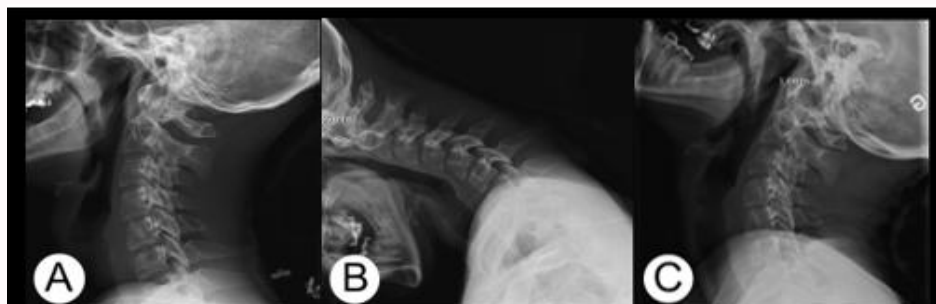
(A) Preoperative radiograph neutral position. (B) Preoperative radiograph flexion position. (C) Preoperative MRI extension position.
